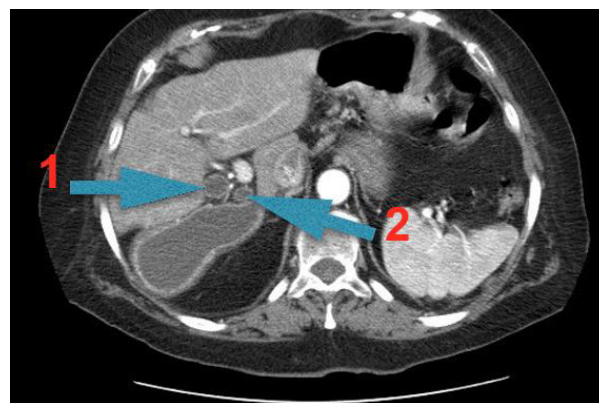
CT image. 1: choledocho. 2: cystic duct.
